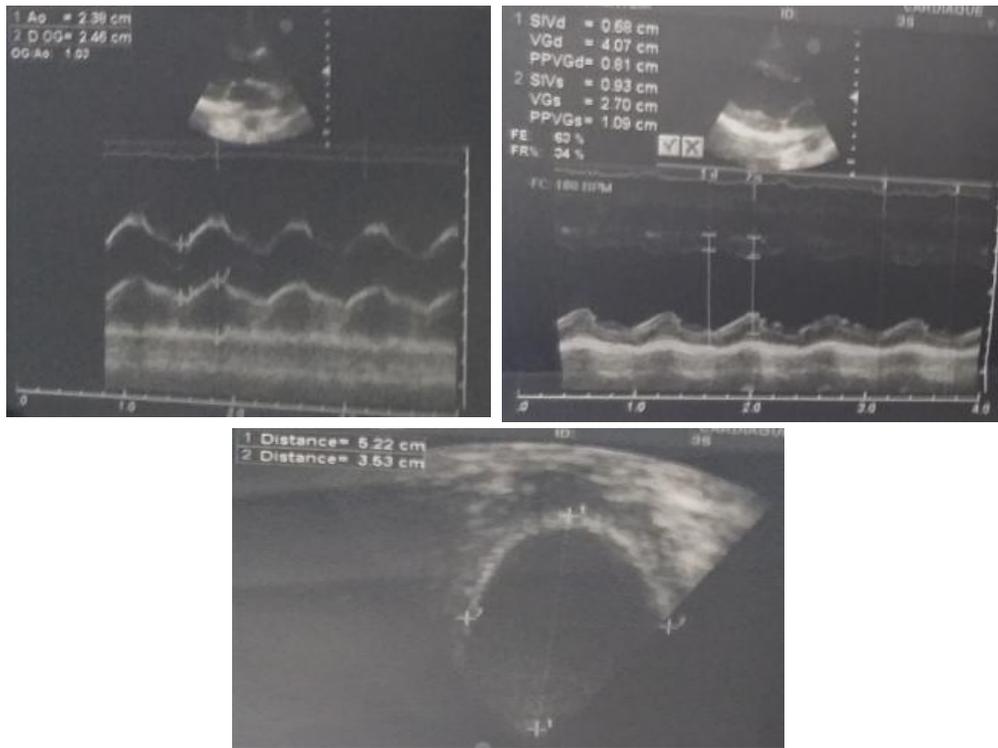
Transthoracic ultrasound revealed a right intraventricular hydatid cyst measuring 52x35 mm
